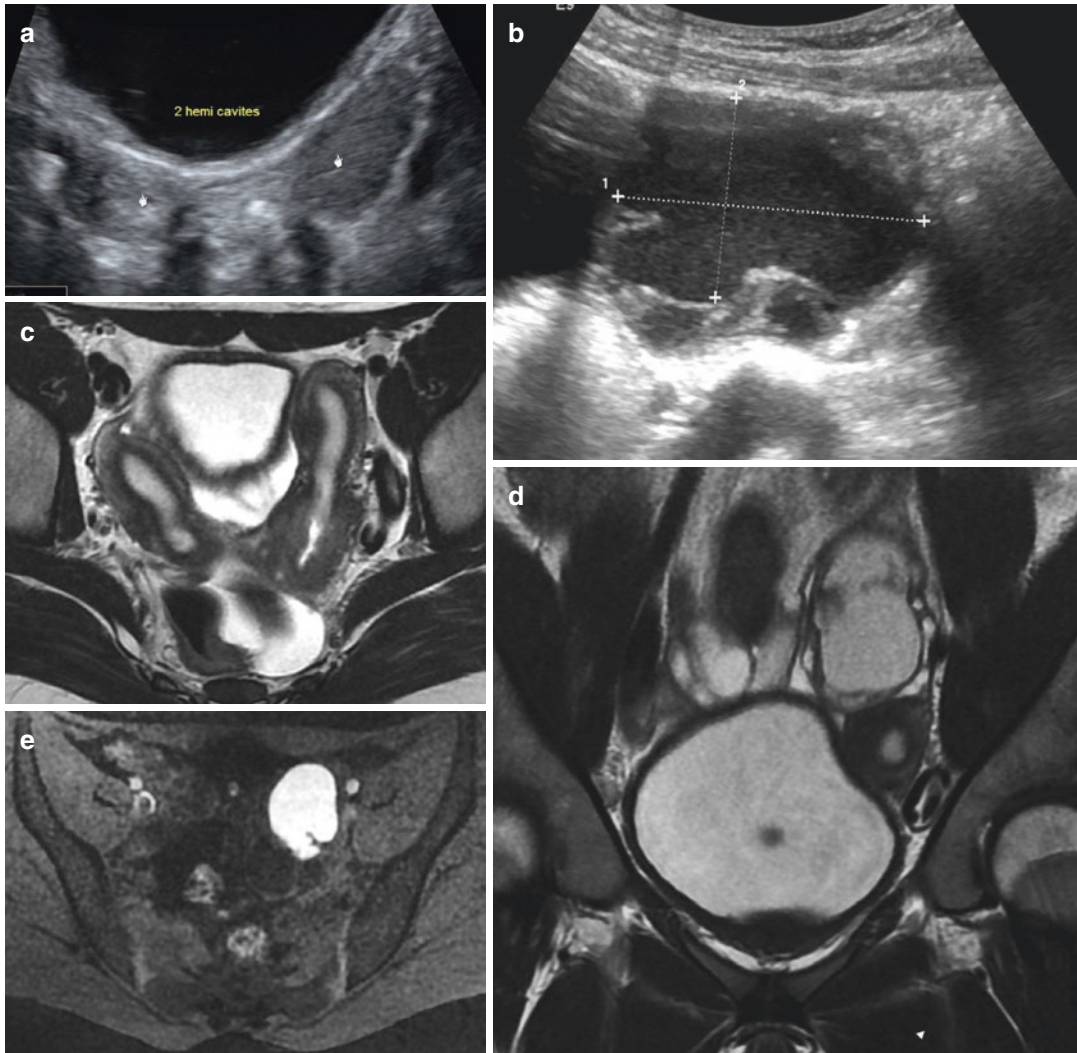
Left endometrioma in a 15 year-old girl with didelphys uterus. (a) US Axial view: Two separate cavities behind the bladder (*heads of arrows*). (b) US Axial view: Unilocular cyst with homogeneous content (ground glass echogenicity) and polycyclic contours. (c) MR imaging: Axial T2-Weighted sequence. Uterus didelphys
